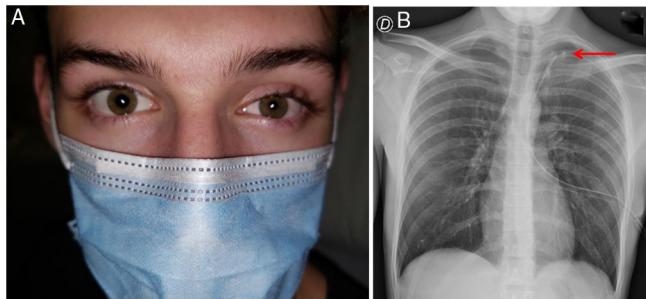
(A) Eyelid ptosis and myosis of the left eye. (B) Chest X-ray: the tip of the pleural drainage tube is seen at the left lung apex (red arrow).
